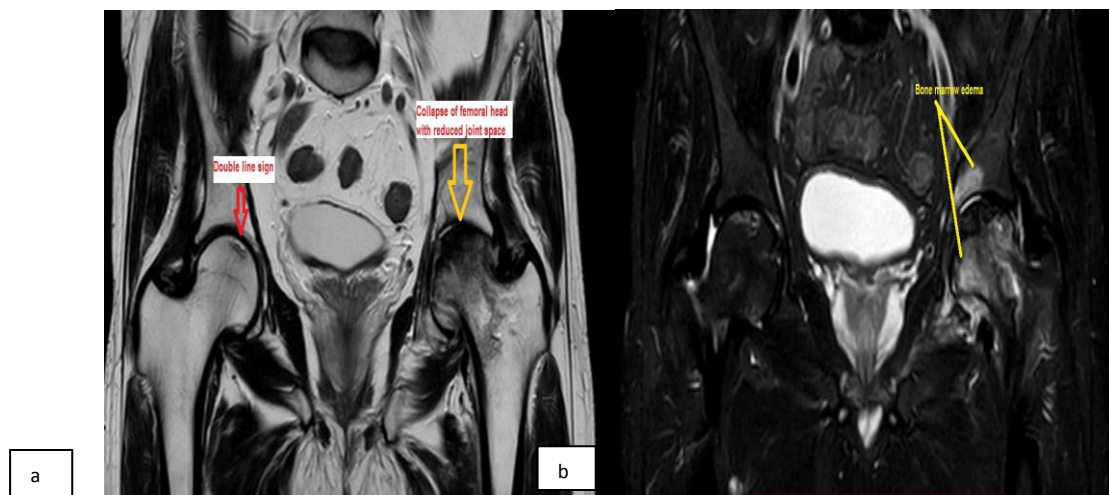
Case of bilateral hip AVN (Ficat and Arlet classification) with Stage II AVN in right femoral head showing double-line sign (seen on T2-weighted sequence and consists of inner bright line representing granulation tissue and surrounding dark zone representing sclerosis) and Stage III in left femoral head showing collapse of left femoral head on T2WI with bone marrow edema on STIR (a) T2 coronal. (b) STIR coronal.
